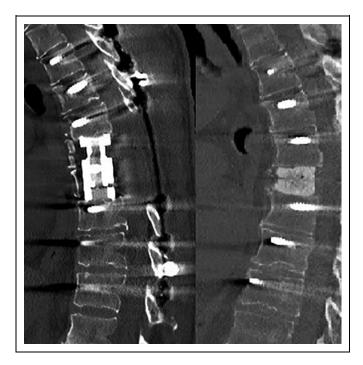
Representative postoperative sagittal CT images of vertebrectomy reconstruction with an expandable cage (left) and polymethylmethacrylate cement (right).
